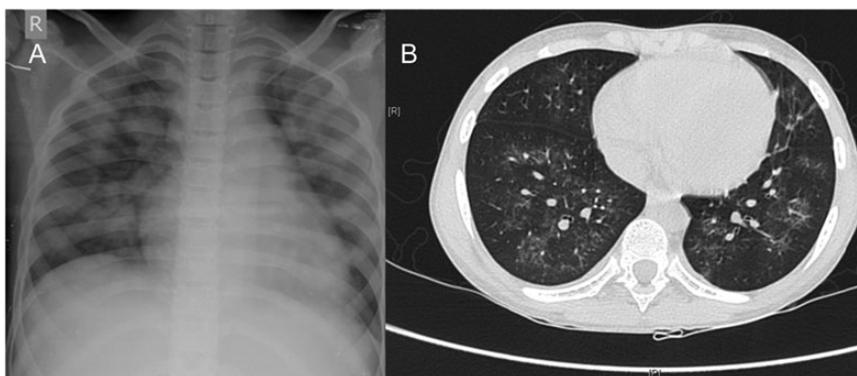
(A) Chest X-ray showing bilateral nodular infiltrates and (B) high-resolution CT chest (transverse view) showing diffuse patchy ground glass opacities bilaterally resulting from alveolar haemorrhage.
